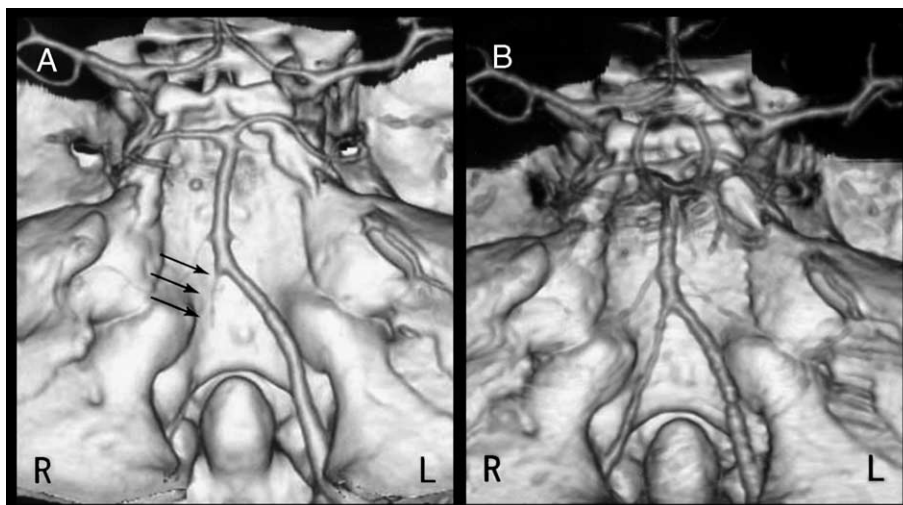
Three-dimensional CT scan. (A) The left vertebral artery with high-grade stenosis (arrows); whereas the other arteries, including the right VA, were normal. (B) Apparent recanalization at the site of the stenosis of right VA 3 months after the onset of dissection.
